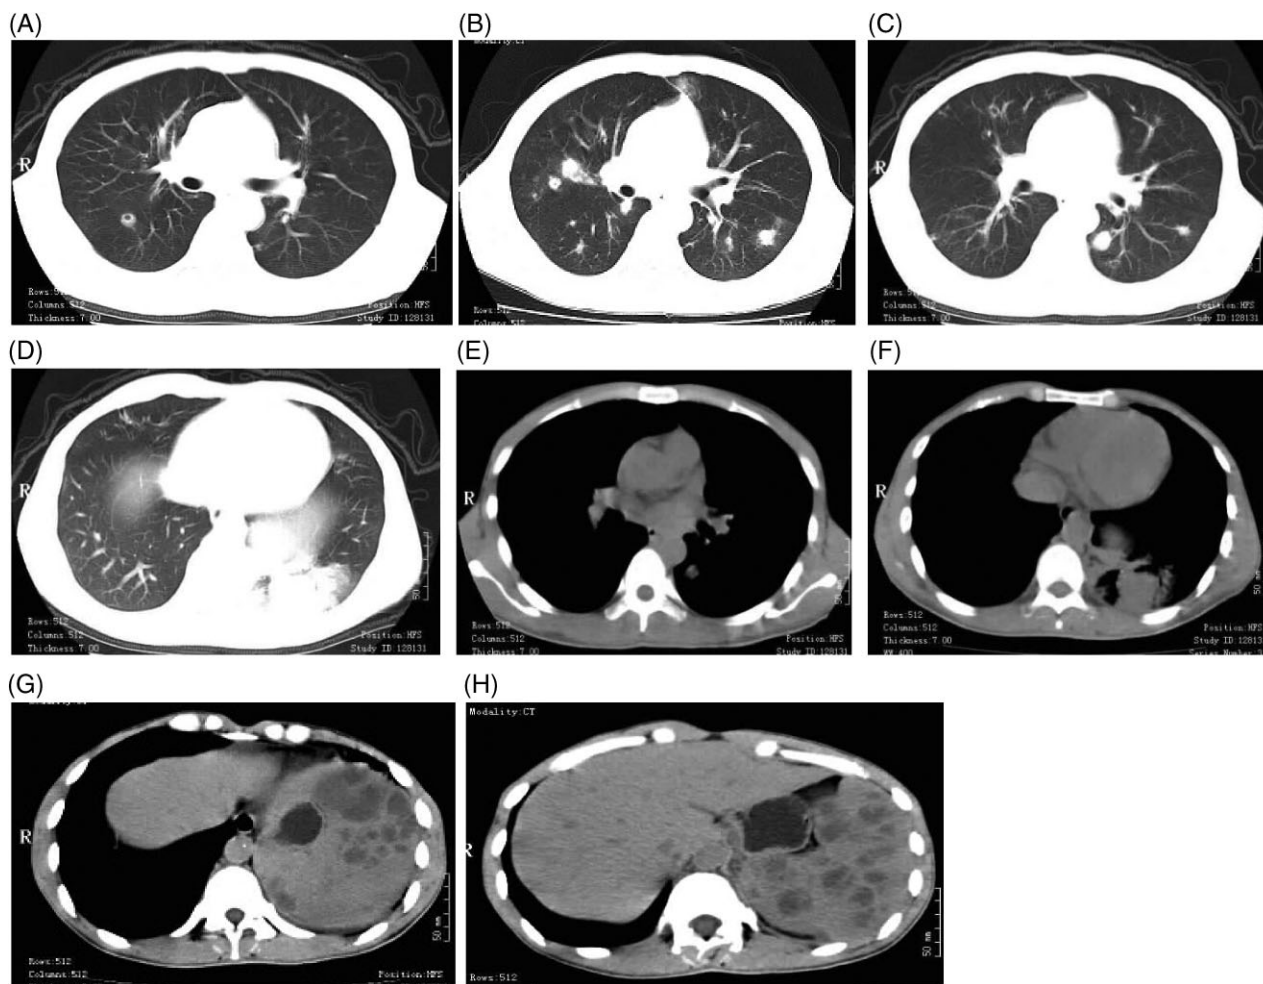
(A–C) chest computed tomography (CT) scans revealed multiple, bilateral poorly defined and peripherally distributed pulmonary nodules. Some foci showed internal cavitation. (D) consolidation lesion in left lower lung lobe. (E,F) CT in mediastinal windows showed cavitating image and consolidation lesions in left lower lung lobe. (G,H) revealed enlarged spleen with the presence of multiple nodules.
